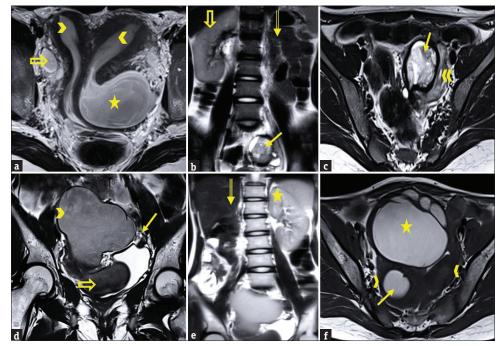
Magnetic resonance imaging (MRI) images of Herlyn–Werner–Wunderlich syndrome, aka obstructed haemivagina and ipsilateral renal agenesis (OHVIRA) syndrome. (a-c) A constellation of features of OHVIRA in patient one, (a) MRI T2 axial maximum intensity projection image showing uterine didelphys (arrowhead), left obstructed haemivagina with haemato-pyometra (star) and right simple ovarian cyst (block arrow), (b) MRI T2 coronal image depicting left renal agenesis (double arrow), normal right kidney (block arrow) and left ovarian haemorrhagic cyst (arrow), (c) MRI T2 axial image showing left ovarian haemorrhagic cyst (arrow) with left haematosalpinx (double arrowhead), (d and e) A constellation of features of OHVIRA in patient two, (d) MRI T2 coronal image shows large right haematosalpinx (arrowhead), obstructed right haemivagina with haematocolpos (block arrow) and normal left ovary (arrow), (e) MRI T2 coronal image shows right renal agenesis (double arrow) and normal left kidney (star), (f) MRI T2 axial image shows uterine didelphys (arrowhead), right haematometra (arrow) and right haematosalpinx (star)
